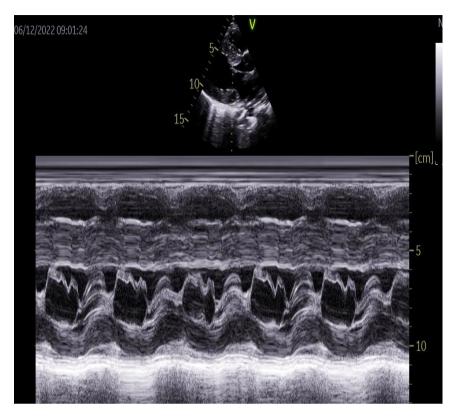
Echocardiographic image objectifying a complete MAS in the first patient
